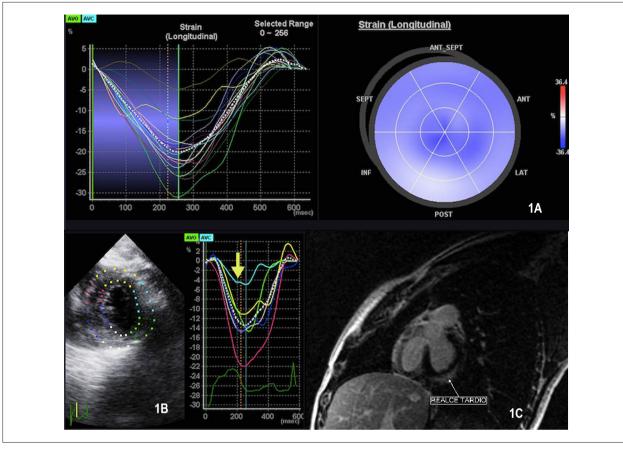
A: Evidence of normal ejection fraction with preserved global longitudinal strain; B: Obvious reduction of circumferential strain in the left ventricular basal inferolateral segment (arrow-light blue line); C: Basal inferolateral late enhancement on nuclear magnetic resonance imaging (confirming the myocarditis process at this level).
